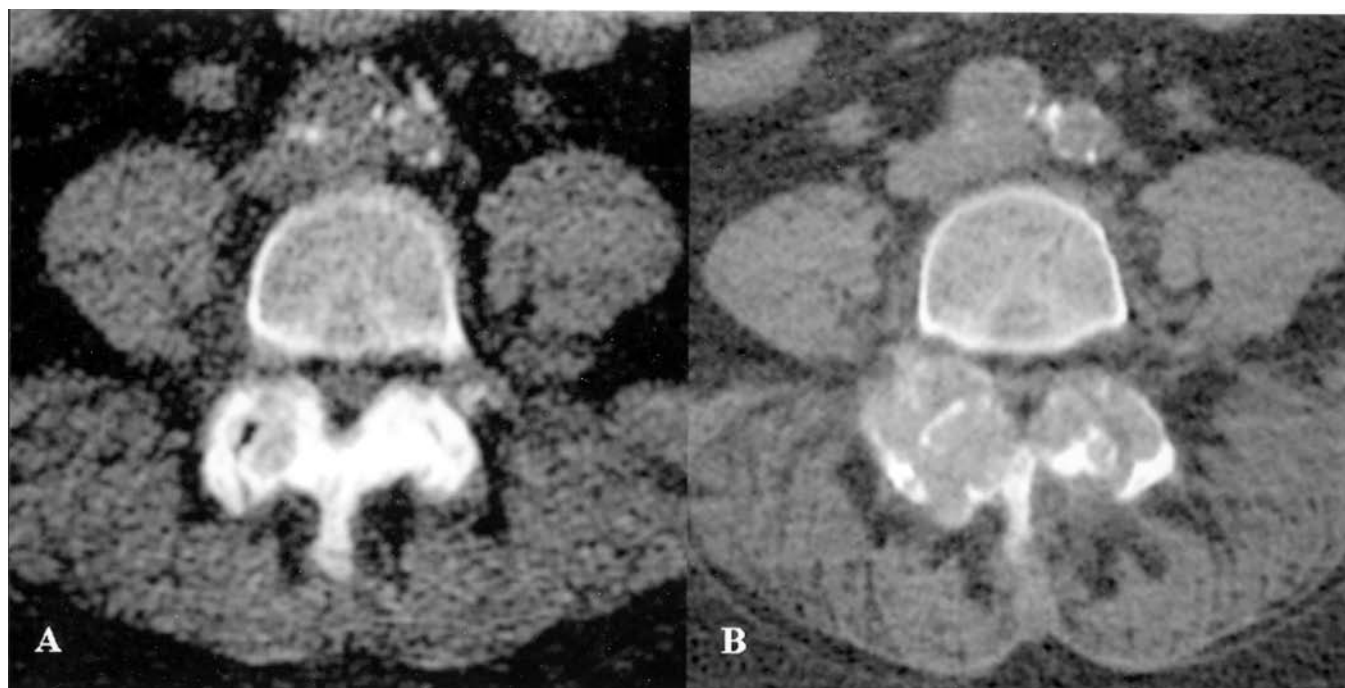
A. CT at L4-L5 level showing a cystic lesion with sclerotic margins at the right facet joint. Study performed 1 year prior to the diagnosis of tophaceous gout. B. CT at L4-L5 at the time of diagnosis. Note the increased size of the described lesion with bilateral involvement of the facet joint and lamina. Intracanal extension of the inflammatory process with associated canal stenosis. Narrowing of the L4-L5 foramen.
